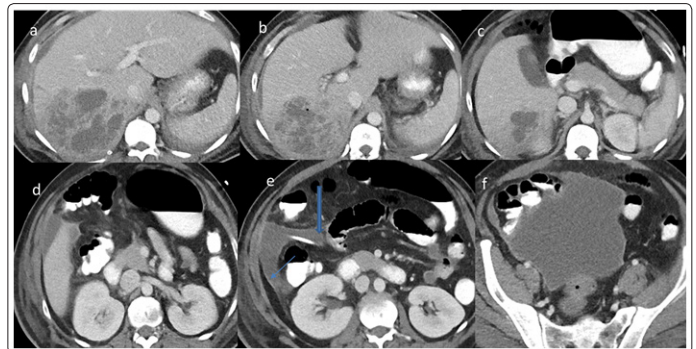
B: CT scan with intravenous contrast done after 10 days of first CT reveals re-demonstration of thin-walled abscess with internal necrotic debris in right lobe of liver. Right pleural effusion (thick arrow in image a), Feeding tube seen (Triangle in image b). Evidence of ascites with peritoneal enhancement (thick arrow in image e), Drainage tube (thin arrow in image e).
